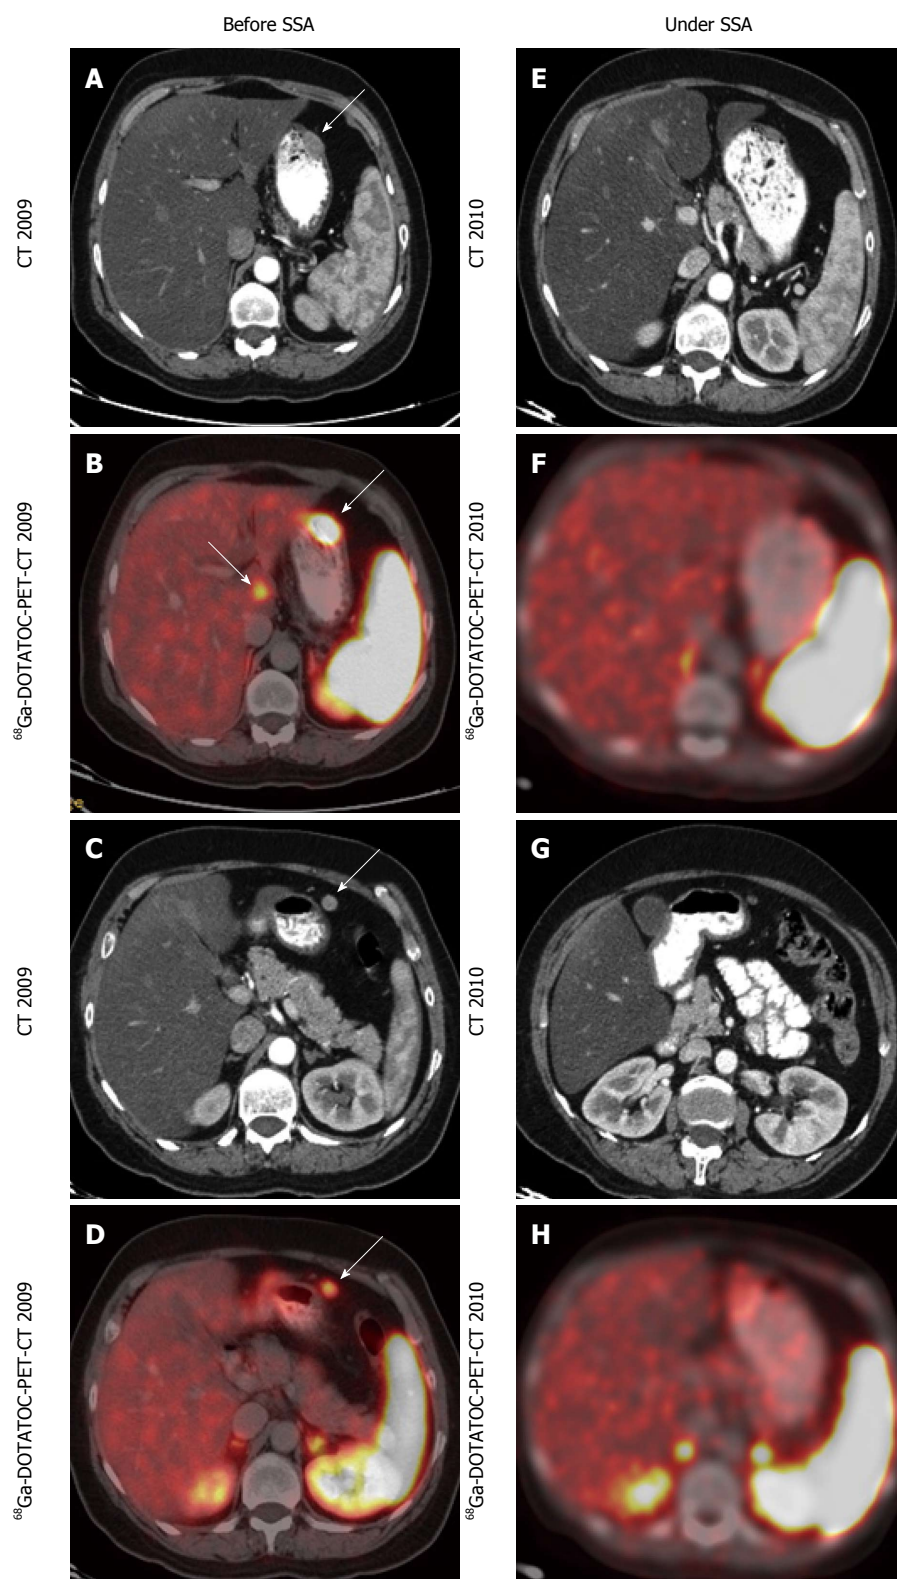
Computed tomography and ^{68}Ga -DOTATOC-PET-Computed tomography images before and during treatment with somatostatin analogue (sandostatin LAR 30 mg/mo). Pathologic uptake in the gastric and hepatic lesion (A + B) adjacent lymphadenopathy and liver lesion (C + D), disappeared on follow up imaging (E - H).
